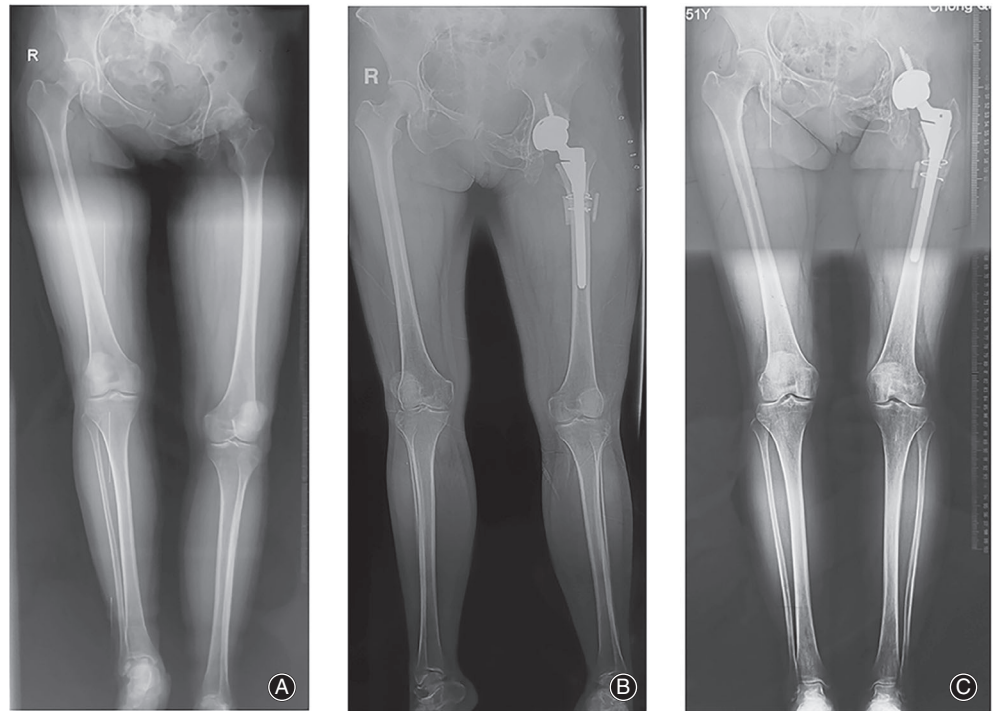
Temporal change of pelvic tilt and leg length discrepancy after direct anterior approach total hip arthroplasty with STO. Standing full-length anteroposterior radiography of the lower extremity before surgery (A), 1 month after surgery (B), and 6 months after surgery (C).
